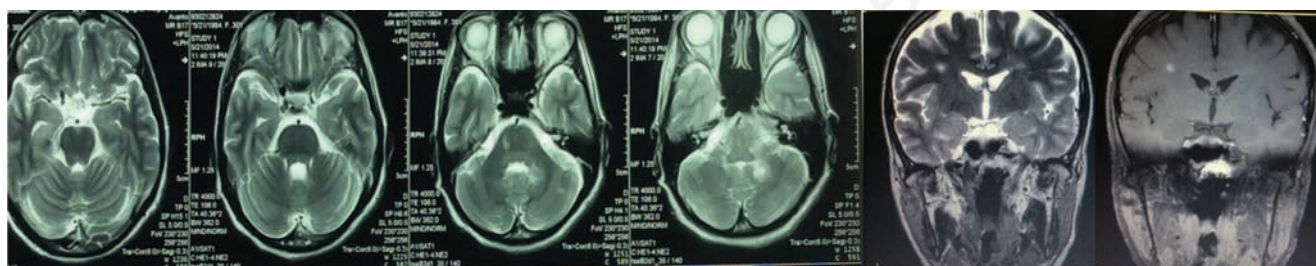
T2/W brain magnetic resonance imaging showing multiple hypersignal plaques in cerebellum, pons and periventricular cerebral white matter (first 5 panels), with enhancing on T1/W sequences with gadolinium (last panel).
